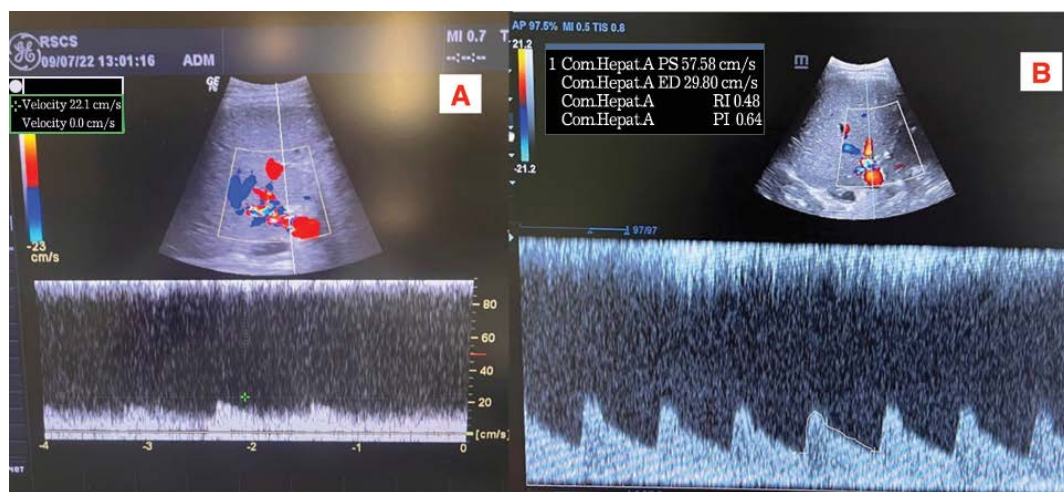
Doppler ultrasonogram. A. A decreased resistance index, decreased visualization of the hepatic artery in a patient with the steal syndrome in the postoperative period. B. Arterial flow characteristics of the same patient after splenic artery embolization
